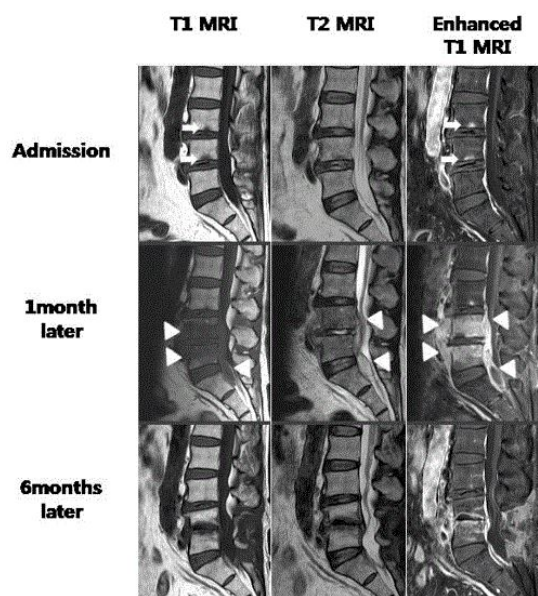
Lumbar magnetic resonance T1-weighted sagittal, T2-weighted sagittal, contrast enhanced sagittal images (MRI). Admission lumbar MRI showing stress fracture on L3 and L4(white arrow). 1 month later, repeated MRI showing Infectious spondylitis on L4, L5 and epidural abscess.(White arrow head). 6 months later, follow up MRI showing decreased infectious spondylitis and resolved epidural abscess
